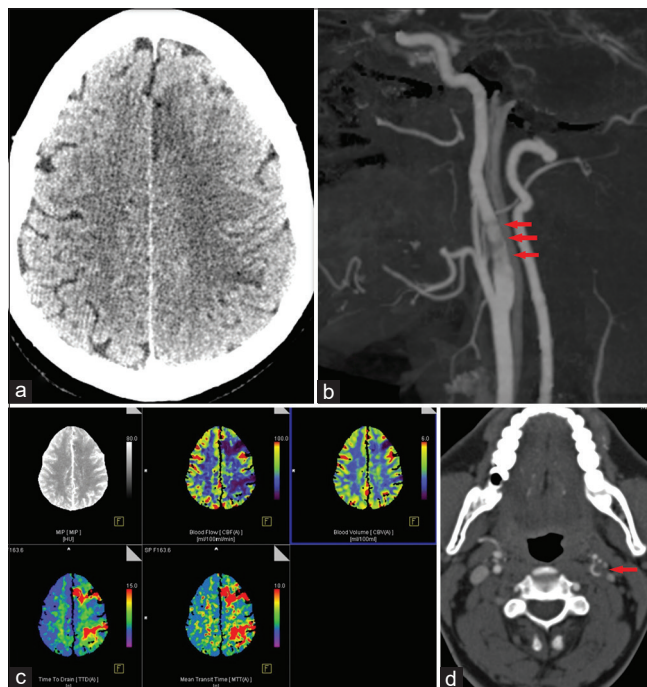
(a) CT Brain showed focal areas of hypodensities suggestive of acute infarcts seen in the left frontal cortex and left MCA-ACA and MCA-PCA watershed territories. Sagittal (b) and Axial (d) CT Angiography showing hypodensity suggestive of free-floating thrombus in the cervical internal carotid artery (ICA) with decreased anterograde signal intensity. (c) CT perfusion showed focal areas of matched perfusion deficit in the left frontal cortex and left MCA-ACA and MCA-PCA watershed territories
